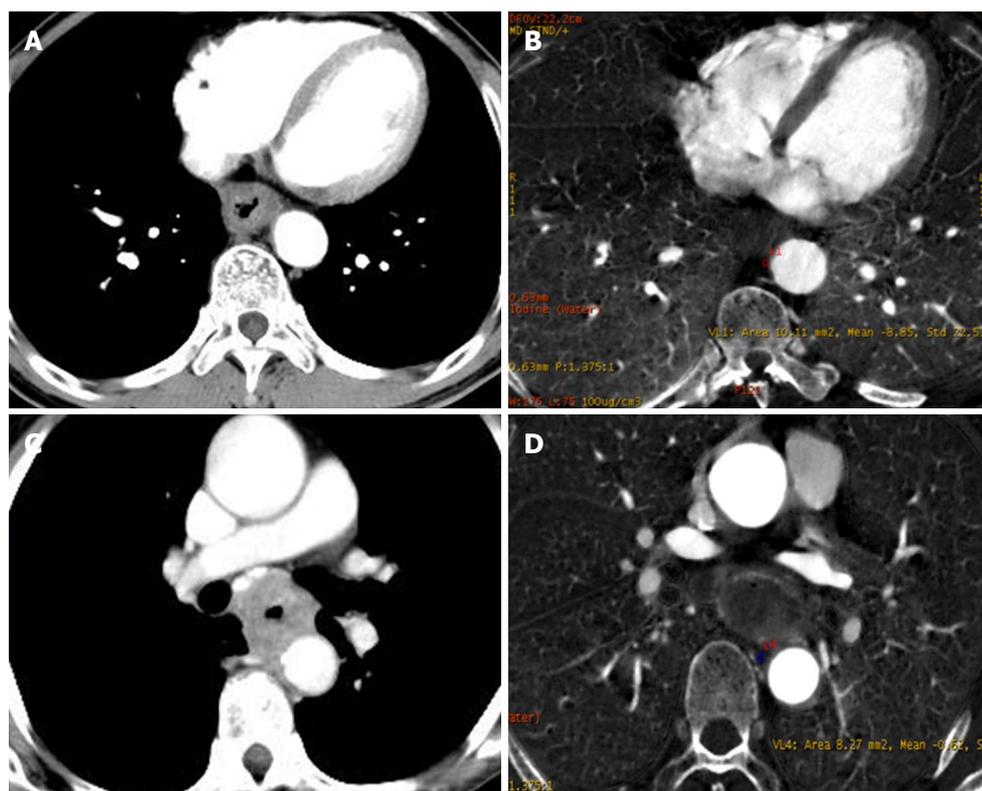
Typical cases showing differences between the T3 and T4 stages of esophageal squamous cell carcinoma. A: Image from a 62-year old patient with T3N0M0 obtained using EICT combined GSI assist shows a clear triangular area in front of the vertebral body. B: IC in the triangle area during the AP was quantified to be $-8.85 \mu\text{g}/\text{cm}^3$, and NIC during the AP was $-0.05 \mu\text{g}/\text{cm}^3$. C: An axial image of a 57-year old patient obtained by EICT combined with GSI assist during the AP shows that the adipose tissue of the triangular area disappeared with suspected tumor invasion. D: IC in the triangle area during the AP was quantified to be $-0.62 \mu\text{g}/\text{cm}^3$, and NIC during the AP was $-0.01 \mu\text{g}/\text{cm}^3$. EICT: Esophageal insufflation computed tomography; IC: Iodine concentration; NIC: Normalized iodine concentration; AP: Arterial phase.
